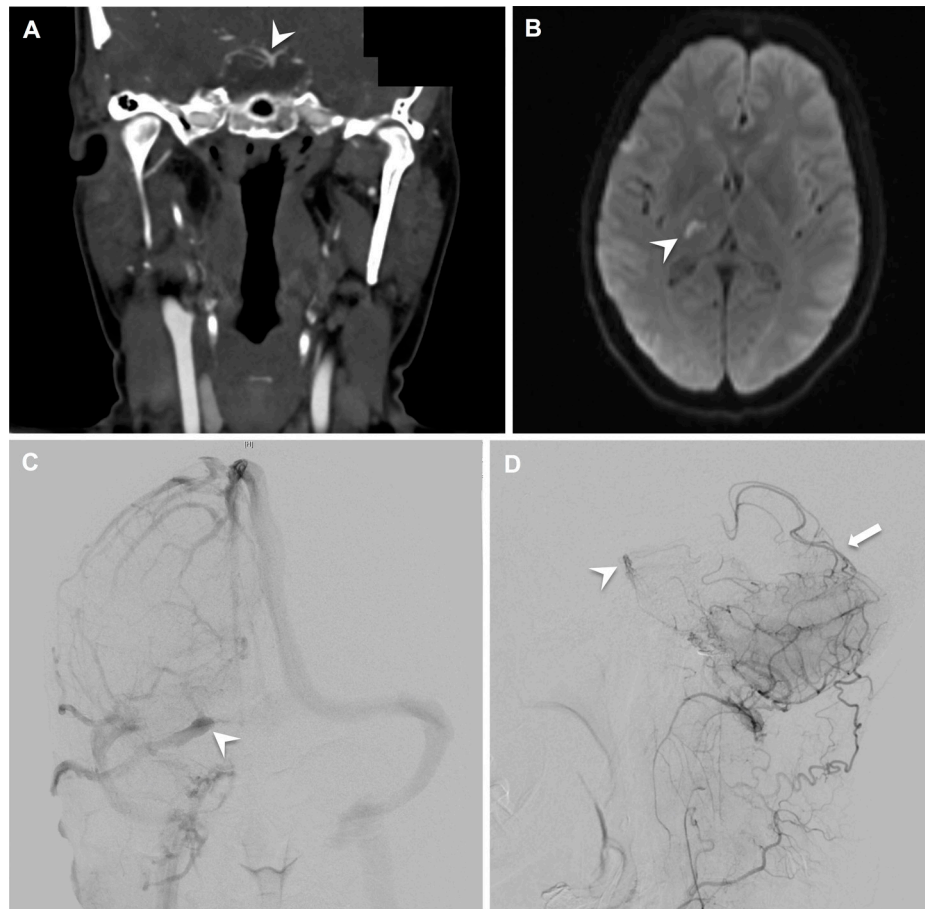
Preoperative imaging. (A) Coronal CT angiography (CTA) taken on presentation to the emergency department demonstrated that the basilar artery and proximal posterior cerebral artery (PCA) were patent (*white arrowhead*). The ECA-PCA graft was not visualised. (B) Axial diffusion-weighted imaging (DWI) revealed a stroke in the right posterior thalamus (*white arrowhead*). (C) Digital subtraction angiography (DSA) showed visualisation of the graft (*white arrowhead*) in the venous phase of the study, demonstrating that the graft was patent but with slow flow. (D) DSA also demonstrated ample collateral perfusion (*white arrow*) of the basilar artery (*white arrowhead*) from vertebral artery and PICA branches.
